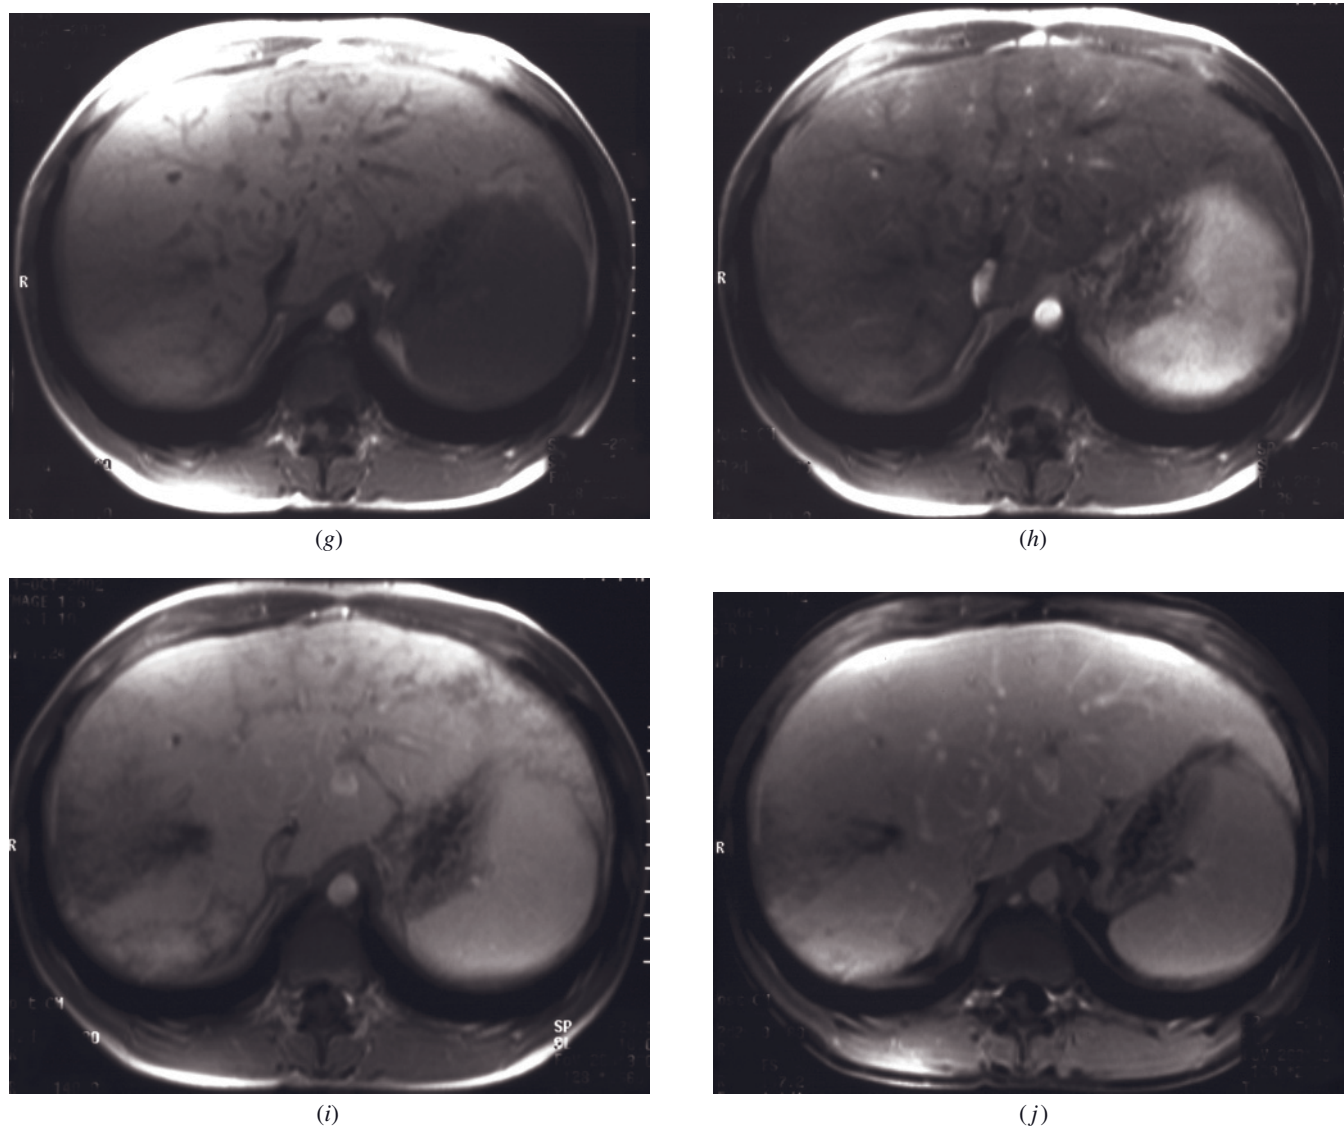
(Continued) T2-weighted fat-suppressed SS-ETSE (*f*), SGE (*g*), and immediate (*b*), 45-s (*i*), and 90-s fat-suppressed (*j*) postgadolinium SGE images in a third patient. The liver is enlarged and shows mild hypertrophy of the caudate lobe. On T2-weighted image (*f*), a triangular shaped segmental area is seen in the right hepatic lobe that shows a higher signal intensity than the remainder of the hepatic parenchyma. On T1-weighted image (*g*), this segmental area demonstrates low signal intensity. On early-phase image (*b*), the liver exhibits a dominant peripheral patchy enhancement that becomes homogeneous on late-phase image (*j*). Note that the segmental area observed on precontrast images (*f*, *g*) shows faint enhancement on early-phase images (*b*) that washes out on 45-s (*i*) and late-phase (*j*) images, consistent with ischemic changes.
